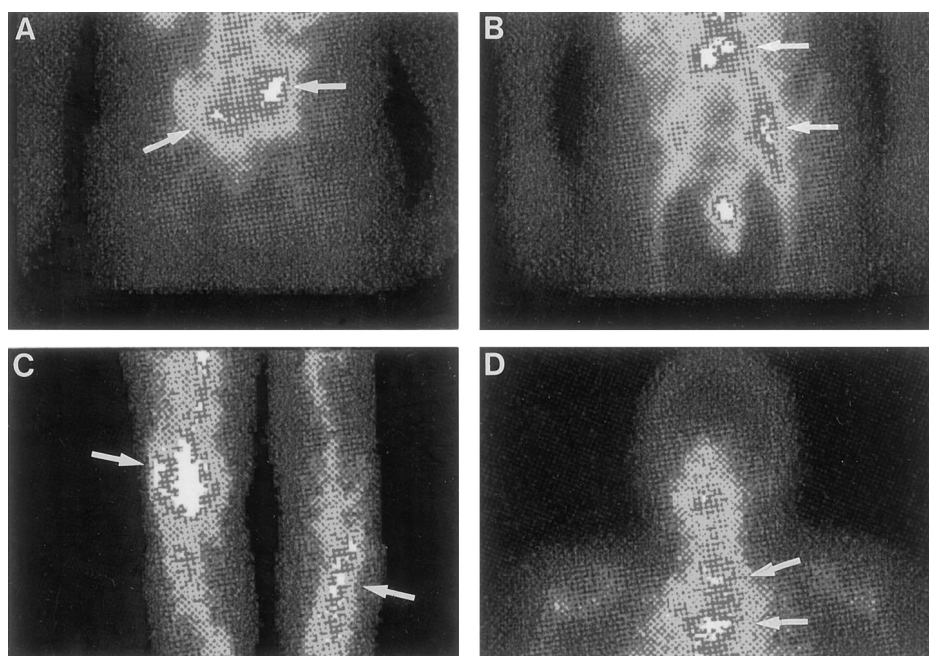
Gamma camera imaging of ¹¹¹In-2IT-BAD-m170 uptake into sites of metastatic prostate cancer in four patients (arrows). *A*, day-3 posterior pelvic view of massive retroperitoneal adenopathy that was also seen on CT and palpable by physical examination. *B*, day-3 anterior pelvic view of retroperitoneal and left inguinal adenopathy that was also seen on CT. *C*, day-2 anterior view of the lower femur, knee, and tibia showing uptake of ¹¹¹In-2IT-BAD-m170 into sites of prostate cancer seen on bone scan and X-ray as extensive, mottled, osteoblastic lesions. *D*, day-6 anterior chest view showing uptake of ¹¹¹In-2IT-BAD-m170 into sternal and manubrial metastasis that were also seen on bone scan.
